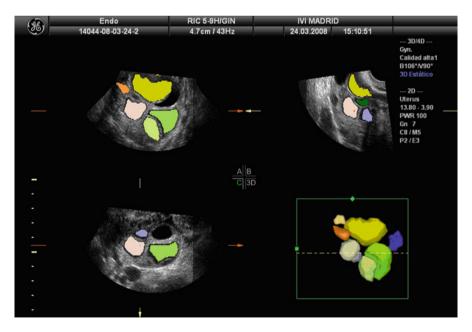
SonoAVC software permits both follicular diameter and volume calculation (automated volume calculation). The operator just needs to capture ovarian volume and the application analyzes and determines diameter as well as volume of the sonolucent areas found. Reproduced with permission, from Puente and Garcia-Velasco. In: Rizk B (ed). Ultrasonography in Reproductive Medicine and Infertility. Cambridge University Press 2010, chapter 8, 70
